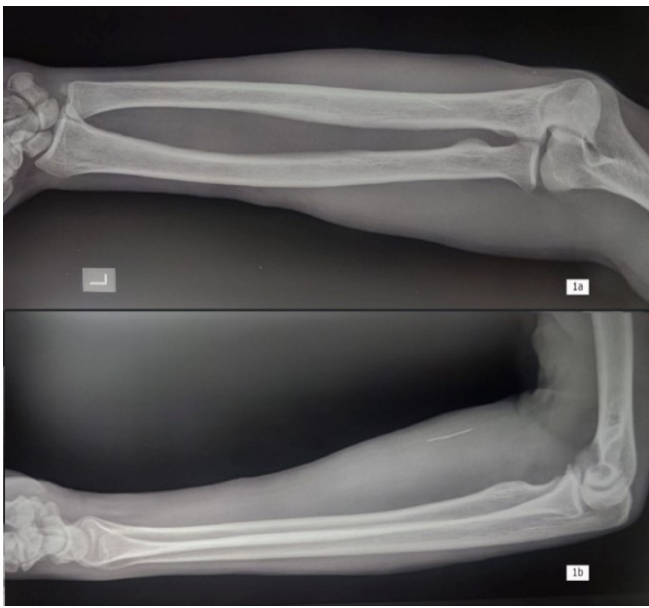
(a and b) Radiographs (anteroposterior and lateral views) of the left forearm confirming the presence of a needle in the proximal forearm.
